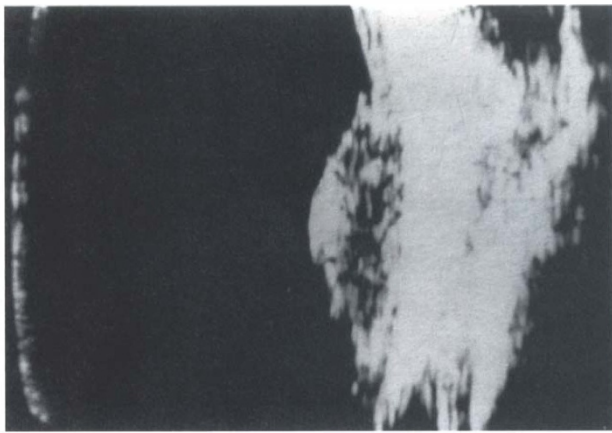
B-scan ultrasonogram done in March 1980, showing a dome-shaped choroidal mass with features typical of choroidal melanoma.
